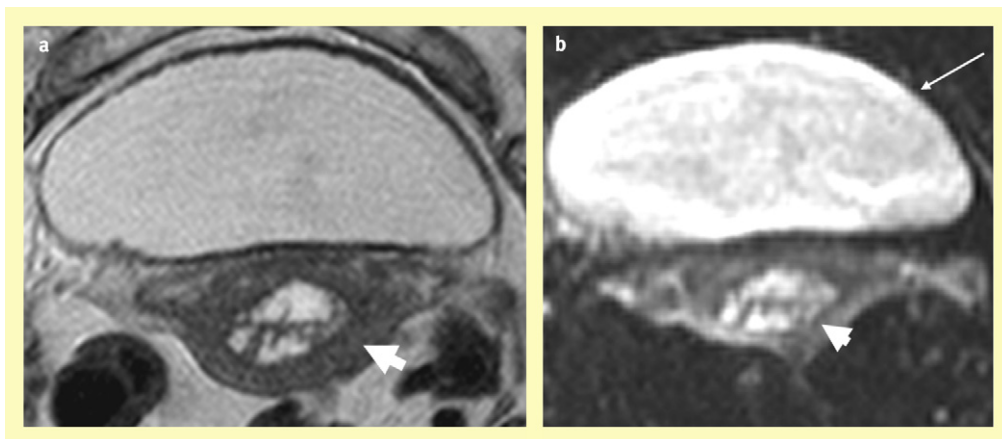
(a) Axial T2W magnetic resonance image demonstrating a high signal tumour within the endometrial cavity (white arrow head). (b) Corresponding axial DWI image demonstrating increased signal representing restricted diffusion within the malignant tissue (white arrow head). As DWI images are inherently T2W, urine in the bladder remains high signal (long white arrow).
